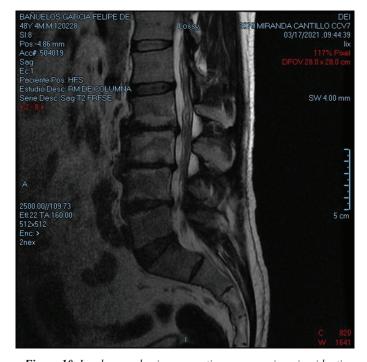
Lumbosacral spine magnetic resonance imaging identifies rectification of the lumbar axis with subchondral degenerative changes, type MODIC II at levels L 2 -L 3, L 3 – L 4, L 4 – L 5; where changes due to spondylosis are added. As well as disc dehydration with bulges in the levels L 2 -L 3, L 3 – L 4, L 4 – L 5, where a narrow channel acquired due to facet hypertrophy is added, in which the lateral recesses are compromised.
